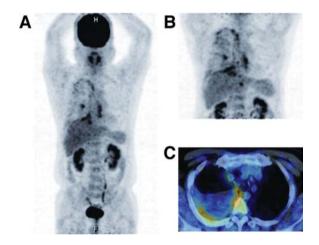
PET/CT findings of a typical MPM patient. MIP PET imaging showed an intense level of abnormal FDG uptake (SUVmax 5.1) in the right thorax at early phase (A) and more intense FDG uptake (SUVmax 5.4) with no metastasis at delayed phase (B). PET/CT showed diffuse FDG uptake in the right pleura with pleural effusion at delayed phase (C).
